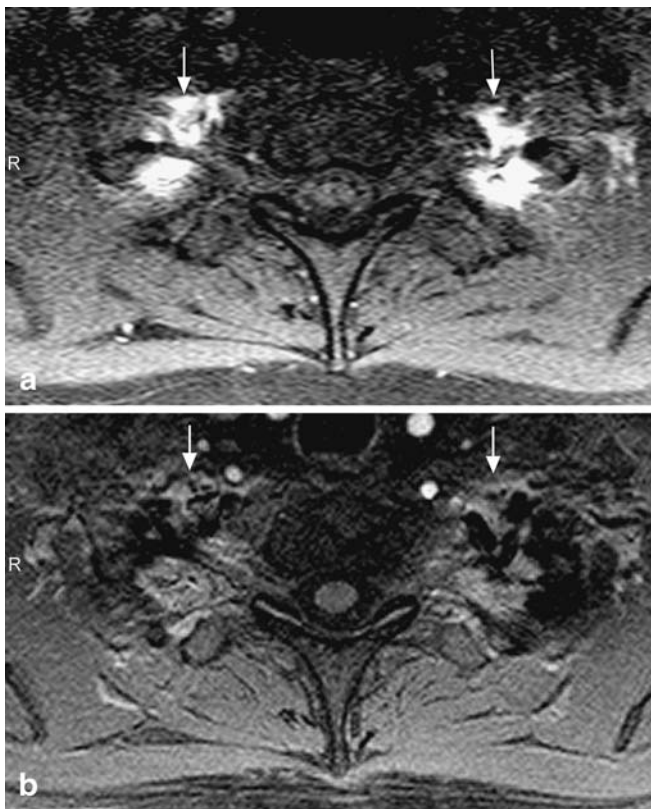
Axial T1-weighted sequence with SPIR (a) compared with the T1-weighted 3D FFE sequence with Proset WATS (b) shows a complete suppression of the hyperintense signal (arrows) at the apex of the lung in the water excitation technique (b)
